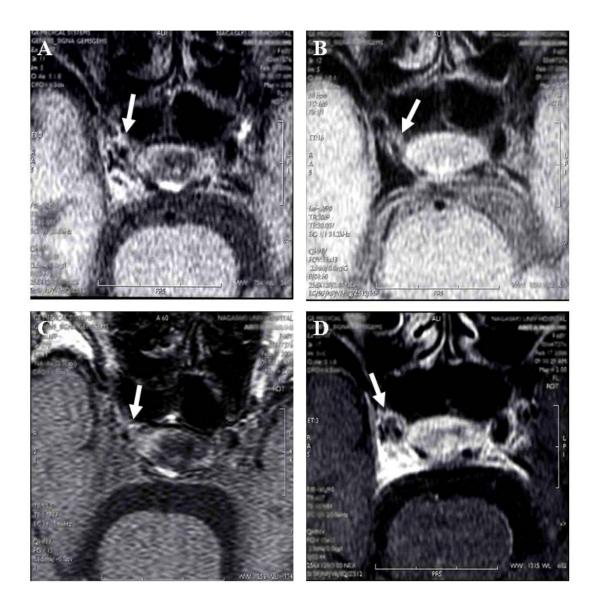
High-resolution magnetic resonance imaging demonstrating the right internal carotid artery plaque (white arrows) to be hyperintense on the T1-weighted imaging (A) and proton density-weighted imaging (B), and slightly hyperintense on 3D time-of-flight imaging (C).The plaque is partially enhanced with gadolinium (D).
